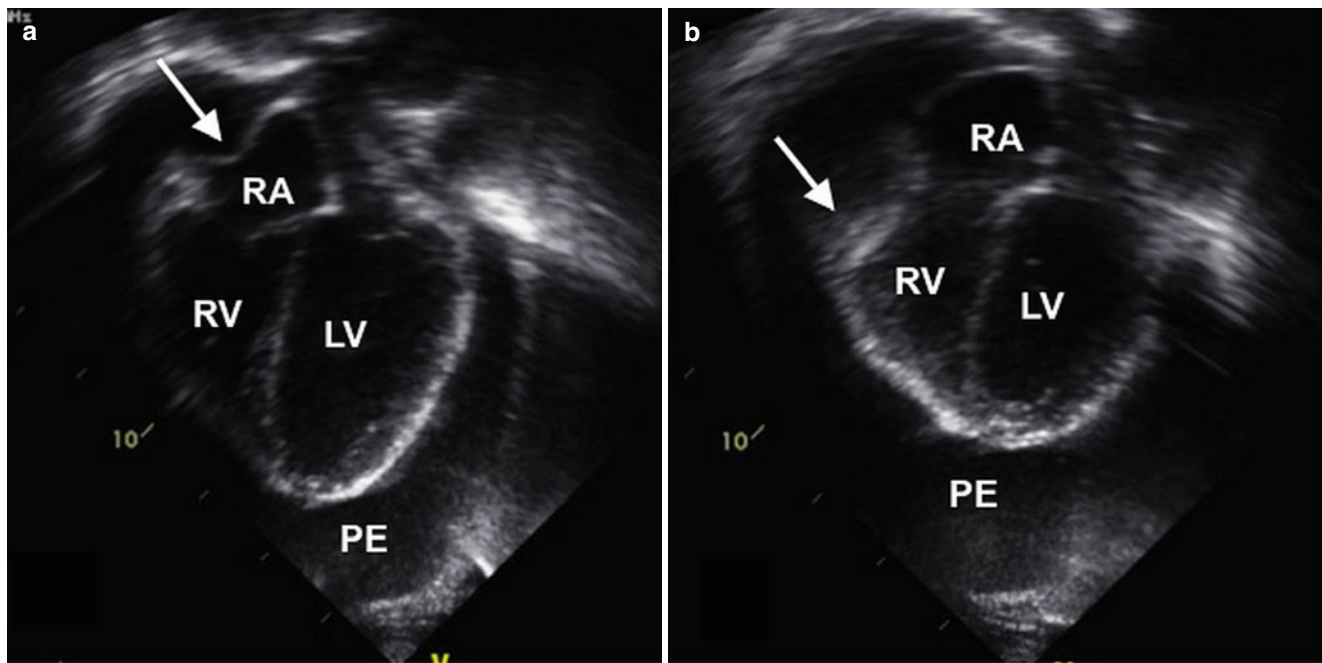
Apical 4-chamber echocardiographic view demonstrating right atrial and right ventricular wall collapse. (a) The large circumferential pericardial effusion can be seen with collapse of the right atrial wall (arrow).
